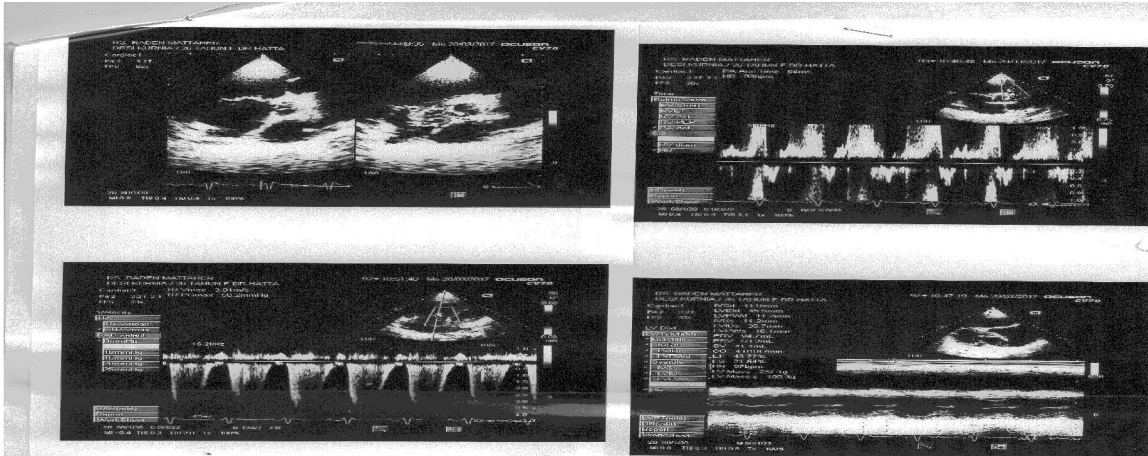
Echocardiography result
